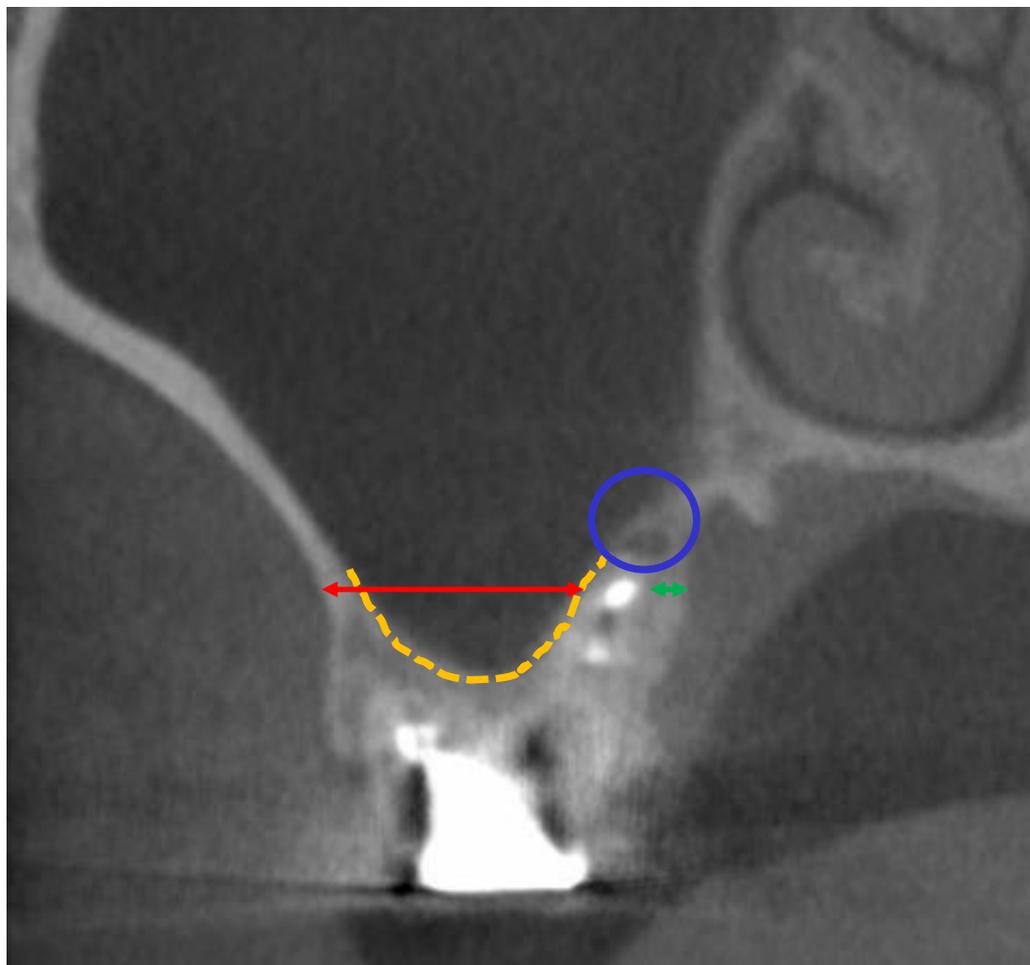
Preoperative cone-beam computed tomographic (CBCT) image. (red arrow) the distance from the buccal surface of the buccal cortex bone to the buccal surface of the palatal root 3 mm below the apex (the root resection level), (green arrow) the distance from the palatal surface of the palatal cortex bone to the palatal surface of the palatal root 3 mm below the apex (the root resection level), (blue circle) the status of the sinus connection with the palatal root or lesion of palatal root origin, and (yellow dotted line) the status of the sinus pneumatization between the palatal root and buccal root.
